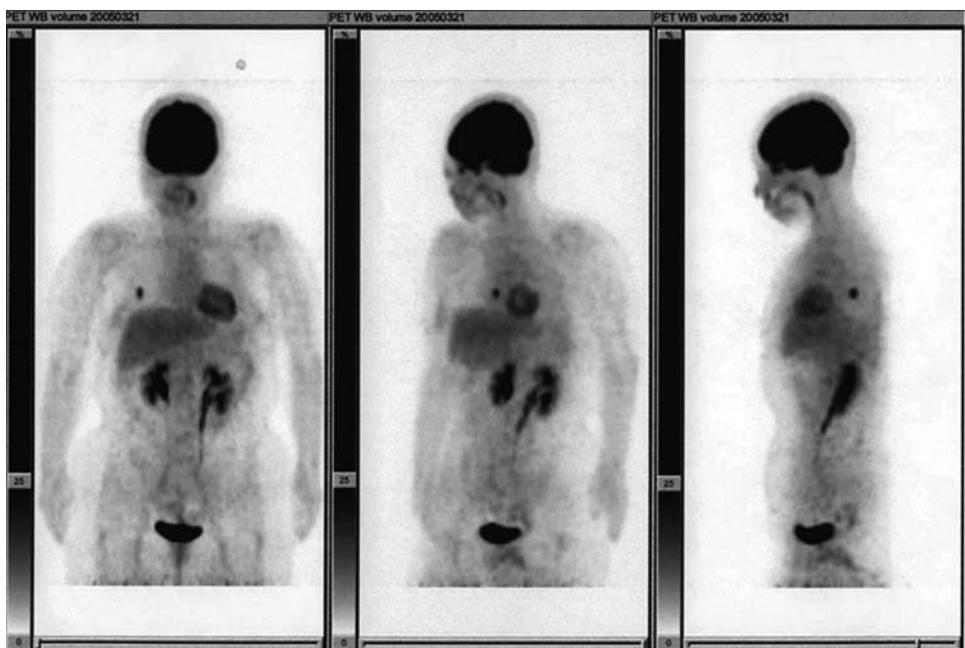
FDG positron emission tomography of a glandular papilloma showing abnormal uptake of the posteriorly located lung tumor, with a maximal standardized uptake value (SUV max) of 10.8.
